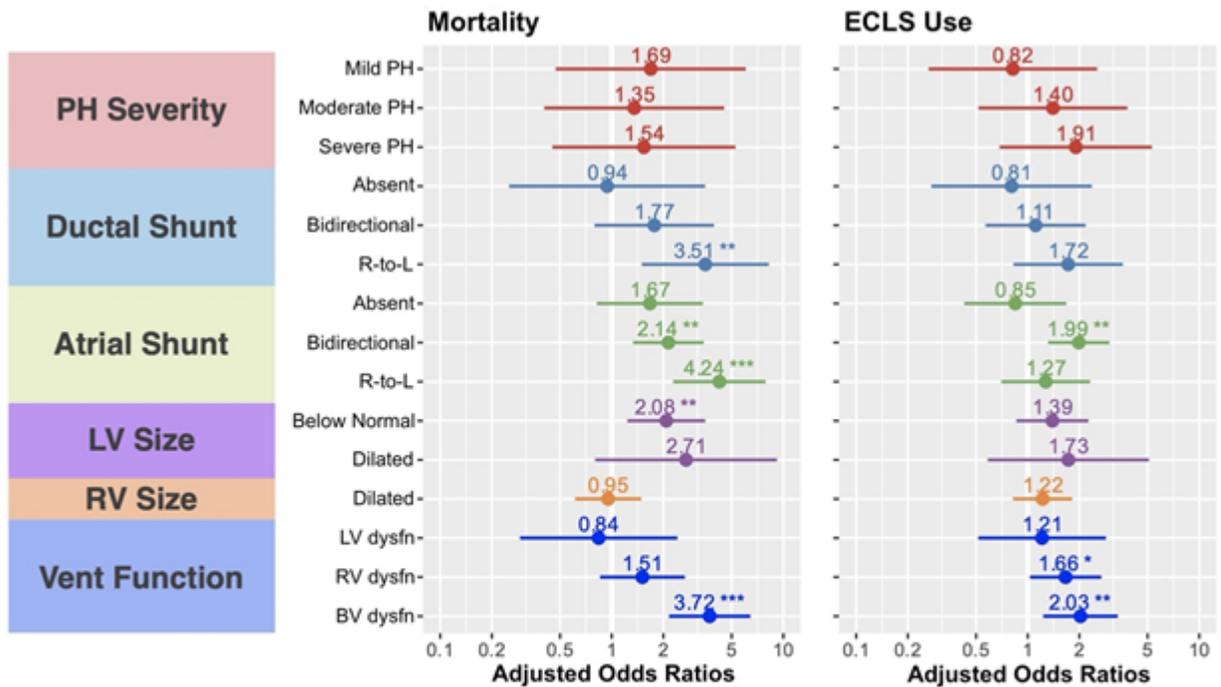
The impact of early echocardiographic characteristics on death and ECLS use based on multivariate regression models. Normal pulmonary arterial pressure, L-to-R shunt, and normal size and function were set as references. Values are presented as 'adjusted OR [95% CI]'. (*, $p < .001$; , $p < .01$; *, $p < .05$) (BV, biventricular; dysfn, dysfunction; PH, pulmonary hypertension; vent, ventricular)
